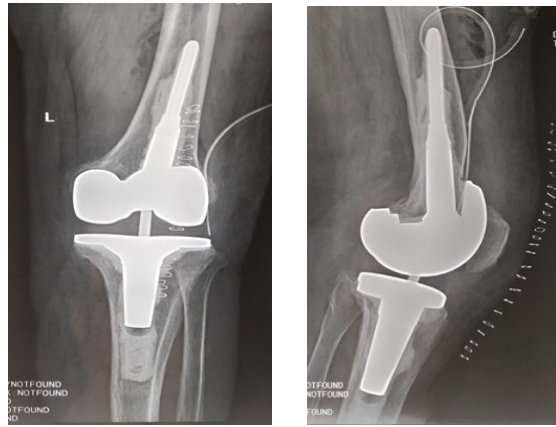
Post-operation x-ray shows no prosthesis loosening happened, Implants placed good position
